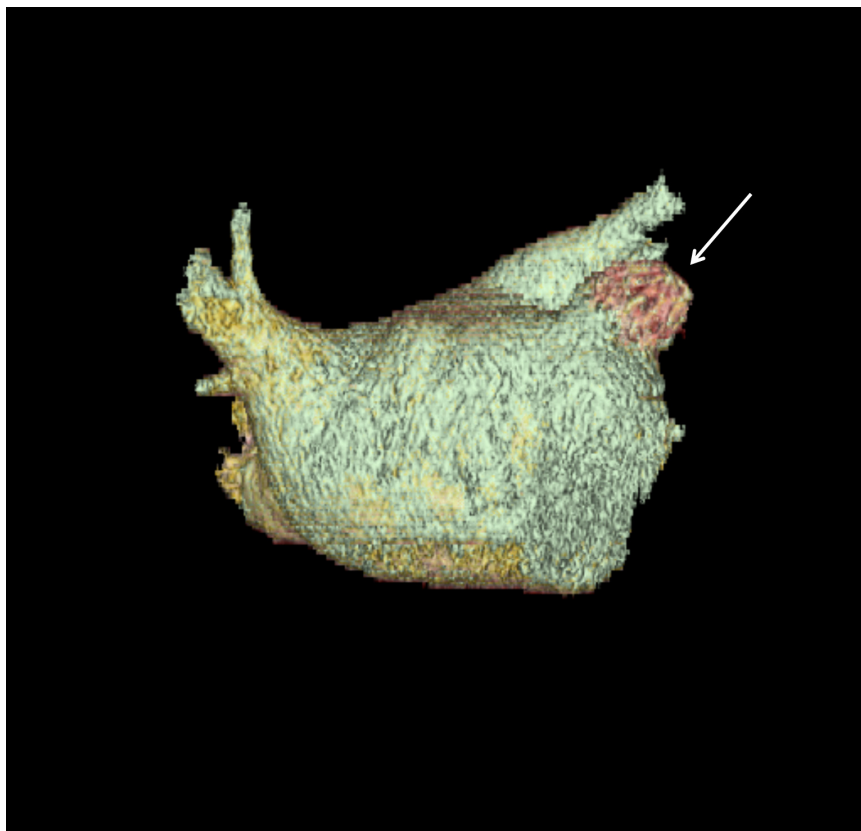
Antero-posterior CT imaging of the left atrium after WATCHMAN® device placement (Arrow).
